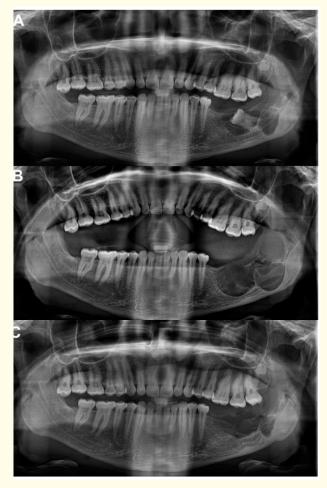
Orthopantomograms (OPG) (A) Before treatment, showing the degree of bone involvement and destruction by the ameloblastomatous lesion. (B) Immediate postoperative OPG, showing the extent of bone loss following the peripheral ostectectomy carried out to remove a safe margin of 1cm from all along the periphery of the lesion to prevent possible recurrence of the Ameloblastoma. (C) OPG taken at 4 months following surgery, showing radiographic evidence of a good bone fill and reossification within the bony cavity, bringing about a marked reduction in size of the defect. No evidence of tumor recurrence or extension was noted.
